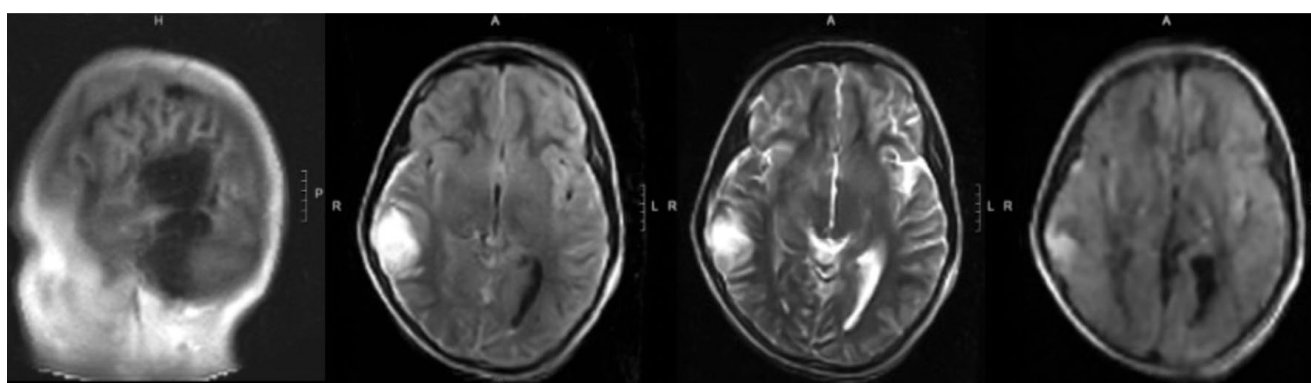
Reprocessed images with research software. Note increased clarity across all images, compared to standard images in Figure 2: (left to right: T1-weighted, flair, T2-weighted and diffusion-weighted images), with permission.
